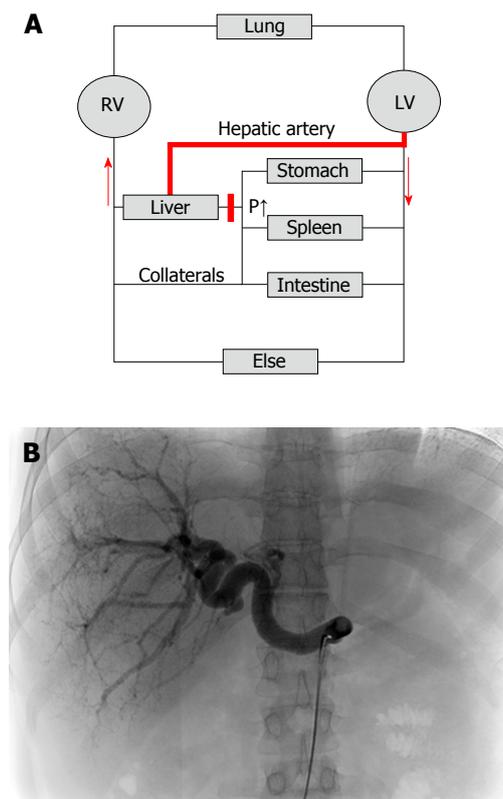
Cirrhotic livers are primarily supplied with blood by the hepatic artery (arterialization). A: Hemodynamics of the low-pressure organ liver in the context of systemic circulation. Cirrhosis causes an increased vascular resistance, collateral formation and increased hepatic arterial flow to maintain hepatic perfusion. Elevated hepatic arterial flow can be observed already before the onset of fibrosis. It eventually leads to a complete arterialization of the cirrhotic liver. In some cases, portal flow completely reverses (so called hepatofugal flow) and hepatic blood exits the liver both via hepatic and portal veins. Note that the blood circulation (red arrows) is functionally maintained by two serial pumps (RV and LV). A dysbalance of these two pumps such as observed during right heart failure can also cause higher SP (congestion) and ultimately cardiac liver cirrhosis; B: Cirrhotic livers are characterized by predominant arterial blood supply. CT angiography of a patient with liver cirrhosis showing a prominent hepatic artery in 31 years old female patient with cryptogenic liver cirrhosis Child A (courtesy of Dr. B. Radeleff, University of Heidelberg). Under such conditions, the hepatic artery supplies the liver with more than 80% of blood. RV: Right ventricle; LV: Left ventricle; CT: Computed tomography.
